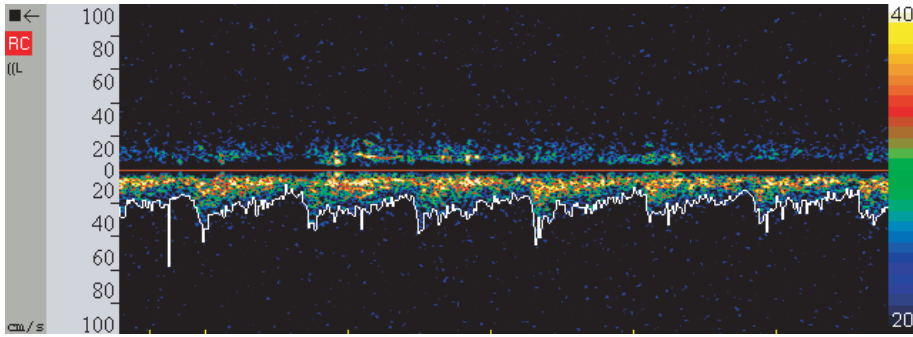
Example of spectrogram from the right posterior cerebral artery as represented by DWL® Doppler software (QL software).
